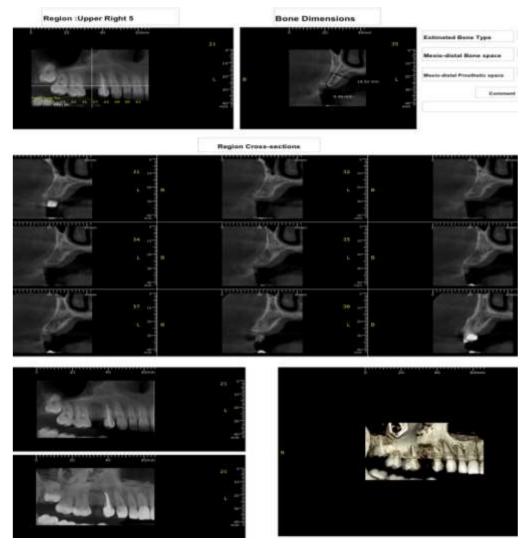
Photograph showing bone height and width using CBCT.
